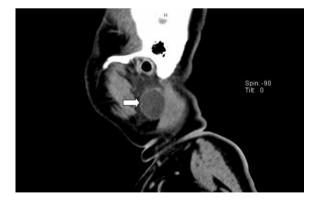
Preoperative CT scan neck sagittal view, Cyst like lesion of the left parotid gland (Arrow)
